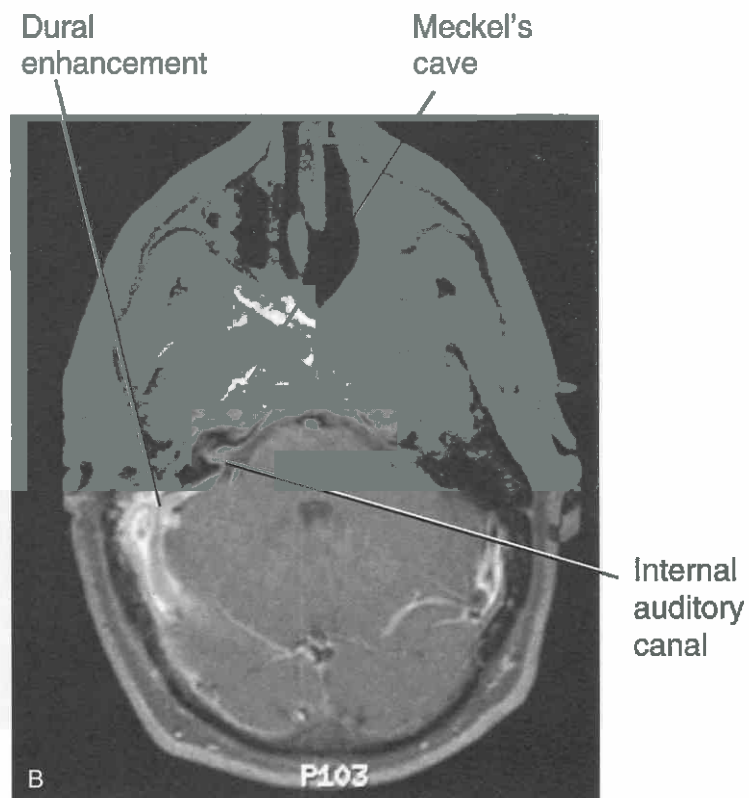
Invasive nasopharyngeal carcinoma in a young man with a very aggressive invasive carcinoma of the nasopharynx that has spread into the adjacent skull base, temporal bone, occipital bone, and posterior fossa. *A*, Axial T1-weighted, spin-echo image with fat saturation. A large arching region of tumor infiltration extends from the posterior margin of the nasopharynx all the way back to near the midline occipital bone. *B*, Axial T1-weighted spin-echo image with fat saturation centered more cephalad than in *A*. There is extensive enhancement of Meckel's caves, the right internal auditory canal, and the dural surfaces of the posterior right temporal bone.
